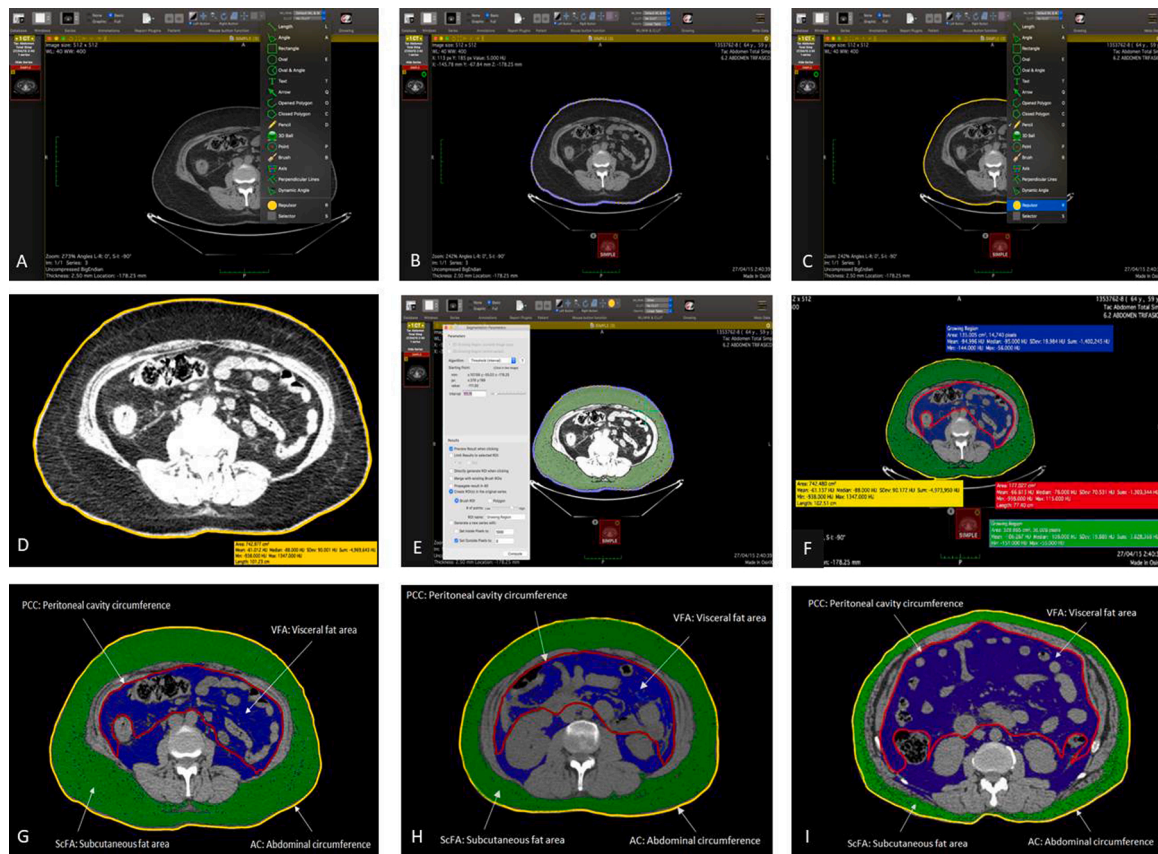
Methodology for segmentation and measurement of intra-abdominal parameters on CT scan images.
